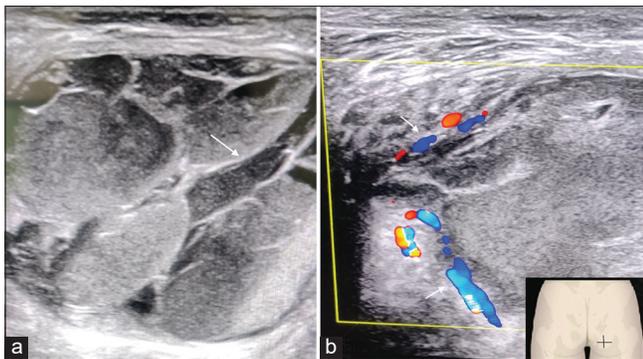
(a) Encapsulated lesion on ultrasound. Note thick internal septations (arrows). (b) Vascularity seen in the walls on color Doppler evaluation.
